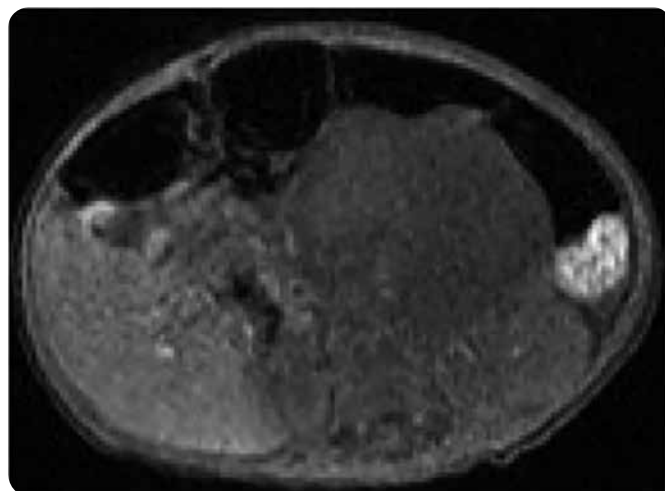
Abdominal MRI, sequence with simple axial T1 information: mass located in the mesentery, oval, low signal, and well-defined contours.
